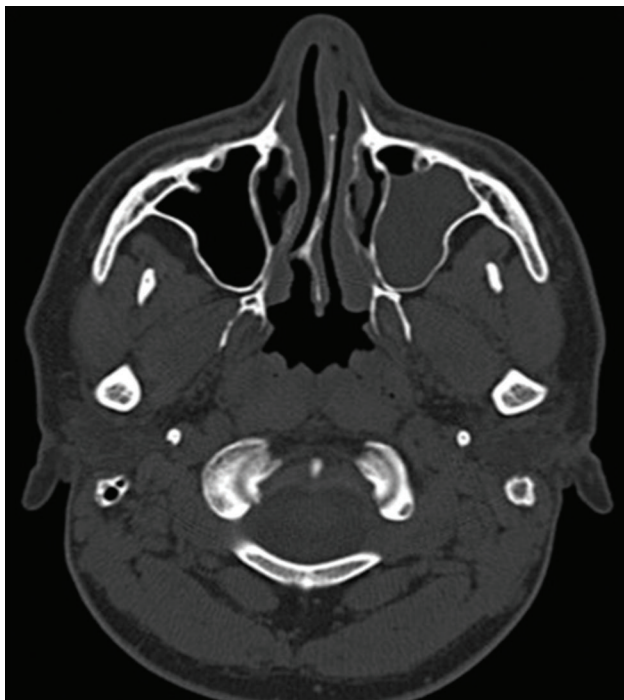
Patient 2: preoperative CT image (coronal view) indicating the reason for making the PST.
